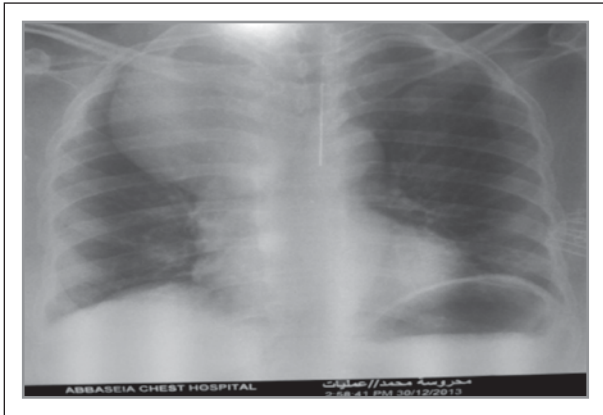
Chest x-ray revealed a mass in the superior mediastinum with tracheal deviation.
